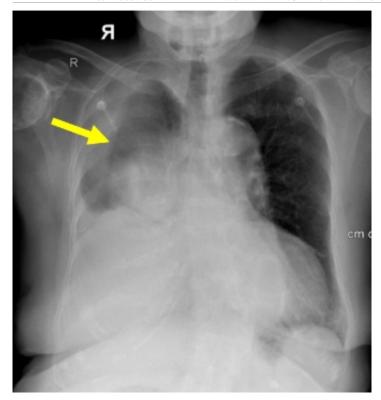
The chest radiograph shows homogeneous opacification of the lower half of the right hemithorax, obliterating the right costophrenic angle and hemidiaphragm. There is a suspicious convex opacity in the right hilar area (pointed) and the left lung shows no active parenchymal opacities.
